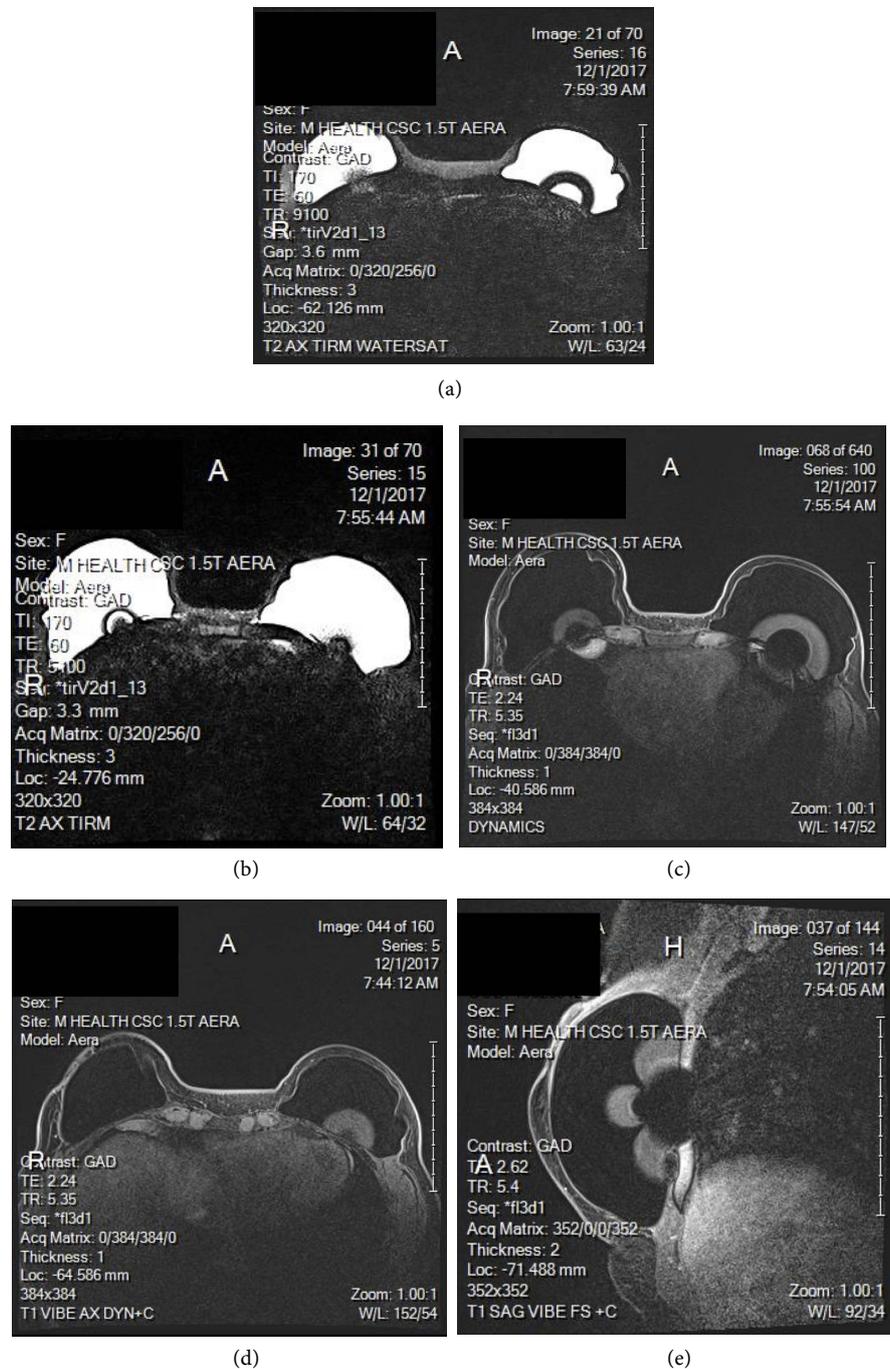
(a)-(e): Bilateral breast MRI without and with contrast on a 1.5 T MRI scanner. The images show minimal background breast parenchymal enhancement (Figure 3(c)). No abnormal suspicious areas of enhancement are seen. No evidence of lymphadenopathy. Bilateral subpectoral silicone implants with susceptibility artifact along the posterior margin of the right and left implant due to RFID device (Figures 3(a)-(e)). There are no suspicious MRI findings. BIRADS 2—recommend annual breast cancer surveillance. (a) Axial T2-WI TIRM sequence with water saturation; (b) Axial T2-WI TIRM sequence with water saturation and artifact reduction software applied; (c) Axial T1-WI subtraction image after administration of gadolinium contrast; (d) Axial T1-WI with fat saturation after administration of gadolinium contrast; (e) Sagittal T1-WI VIBE sequence after administration of gadolinium contrast.
